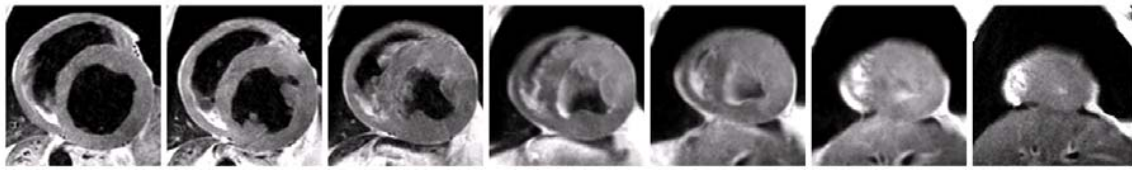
A short-axis stack of T2-weighted images after surface coil intensity correction.
